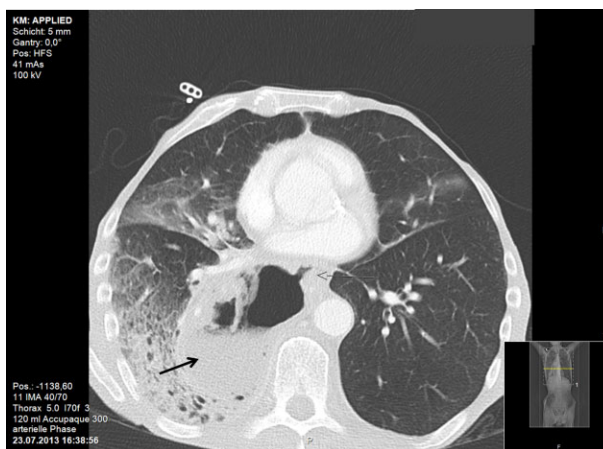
Computed tomography of the chest of case 2, showing an esophagopulmonary fistula (arrow) with a lung abscess in the right lower lobe (black arrow).
